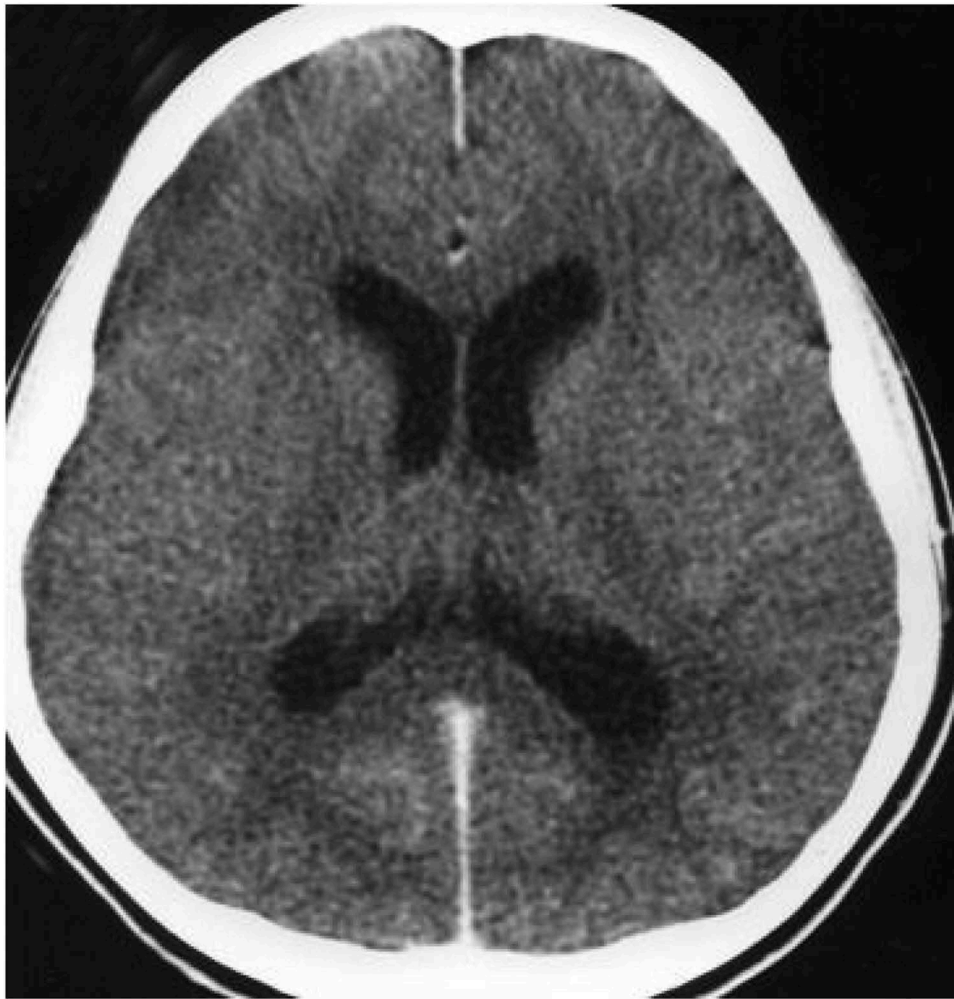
Computed tomography brain showed no signs of raised intracranial pressure or space-occupying lesion.
